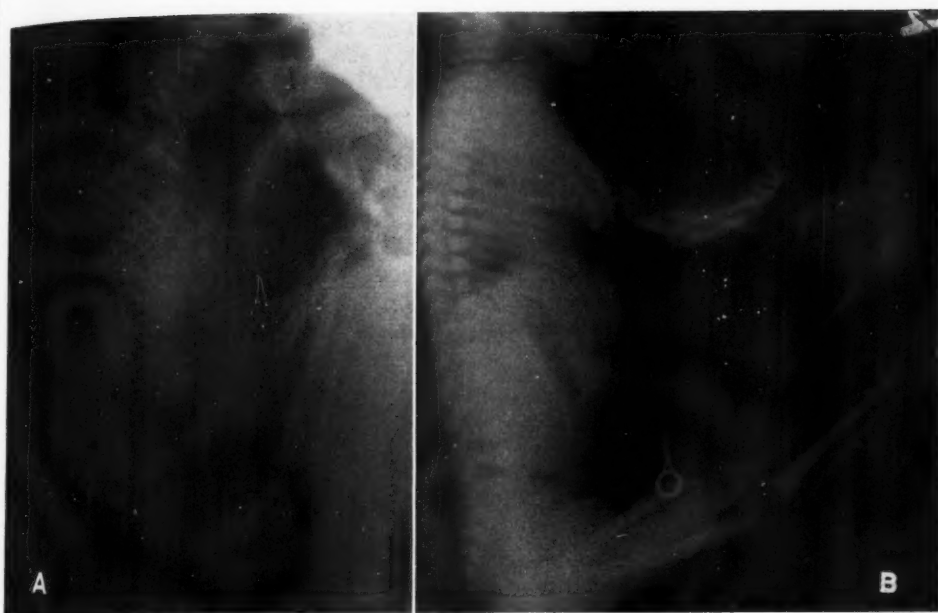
Case II. A. Prepartum lateral abdominal roentgenogram showing full-term fetus in vertex presentation. Note the hyperextension of the lower extremities. The distal femoral epiphyses are shown.
